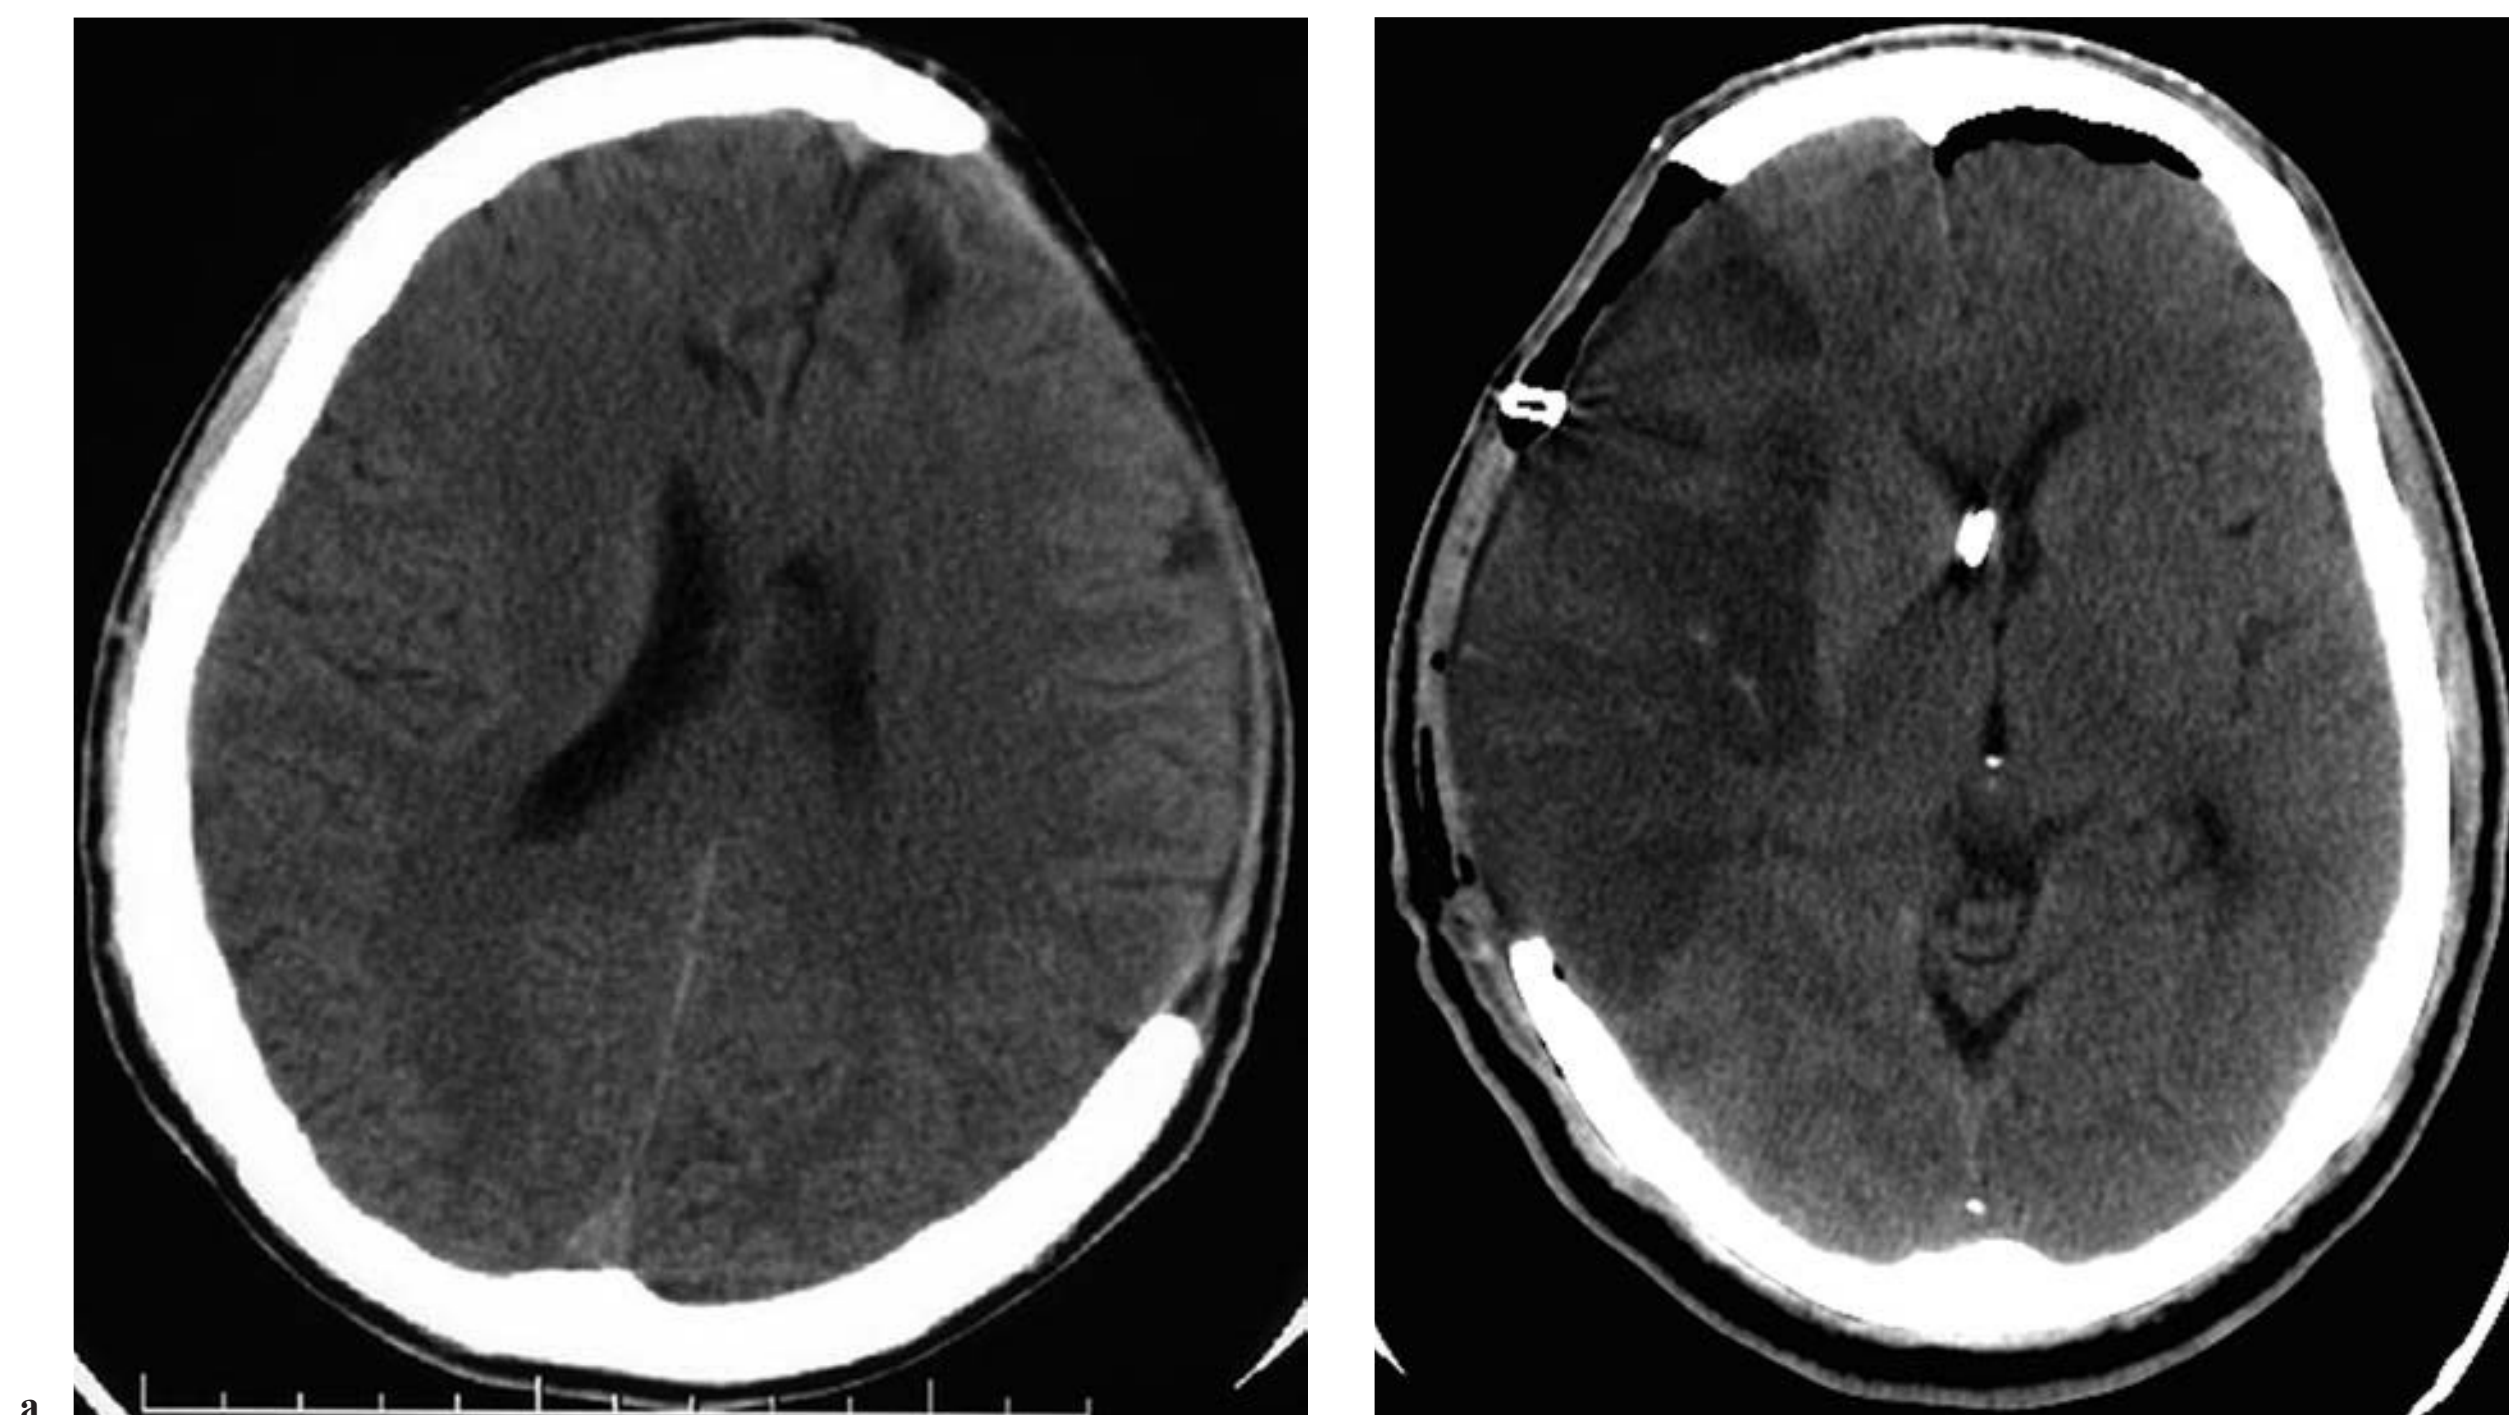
Axial CT images for two patients who underwent decompressive craniectomies for (a) traumatic brain injury and for (b) a large MCA stroke. Note that in the case of the MCA stroke, the craniectomy was tailored to encompass the infarcted area only.
